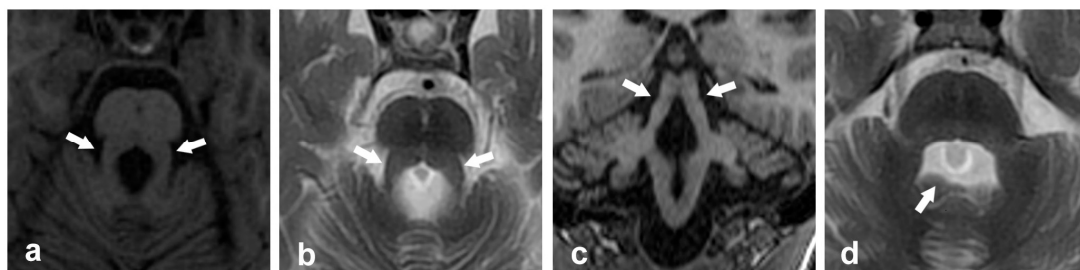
Neuroimaging findings in an 8-year-old child with Joubert Syndrome who experienced psychomotor developmental delay the first months of life and suffers from postural instability and gait ataxia are as follows: (a) axial T1-weighted image and (b) axial T2-weighted image show the thickened, elongated, and horizontally orientated SCP (arrows) at the level of the ponto-mesencephalic junction (molar tooth sign), (c) coronal T1-weighted image displays thickened SCP (arrows), and (d) axial T2-weighted image reveals a bat wing-shaped 4th ventricle (arrow).
